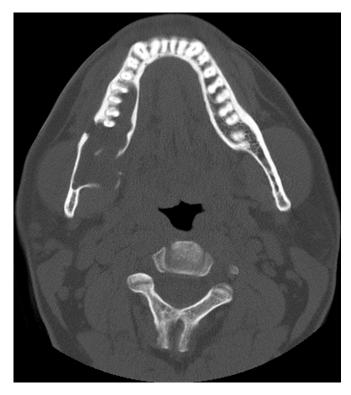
Axial computed tomography image of an odontogenic keratocyst located posteriorly in the mandible. Lucent minimally expansile lesion oriented along the axis of the mandible. Note the cortical dehiscence.
